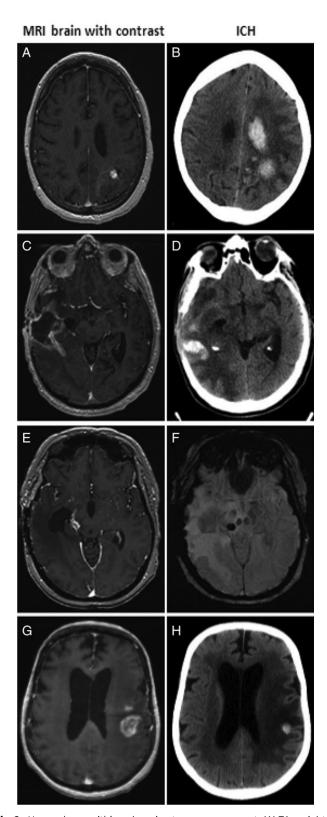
Hemorrhage within enhancing tumor component. (A) T1-weighted MRI with contrast of a patient treated with enoxaparin with a noncontrast CT head, (B) obtained 4 weeks later demonstrating hemorrhage within the enhancing tumor with intraventricular extension; (C) T1-weighted MRI with contrast of a patient on enoxaparin with a noncontrast CT
